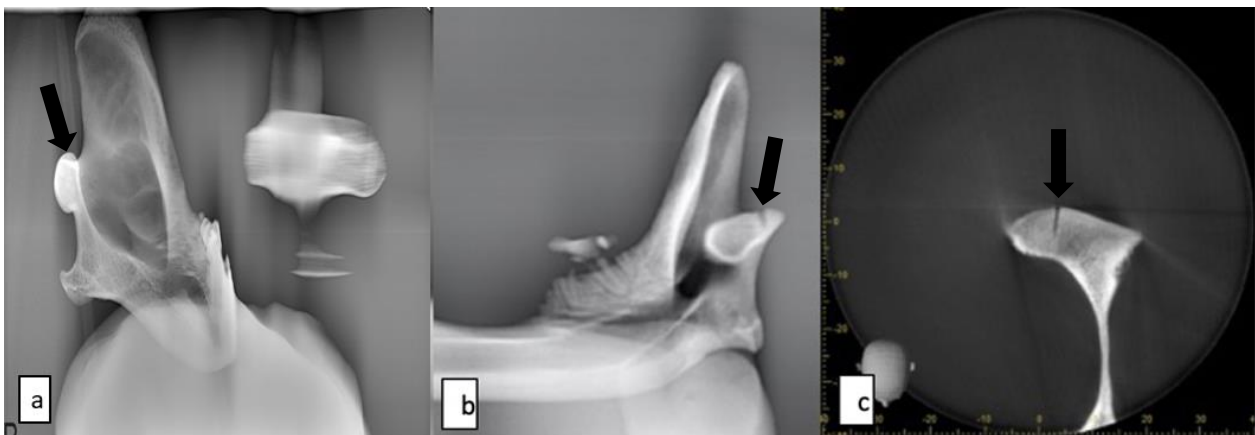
(a,b,c). Panoramic, LSP and CBCT images with vertical condyle fractures were seen.
